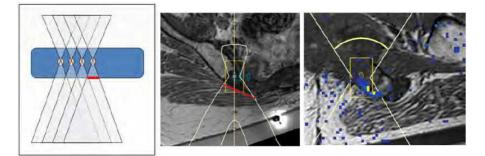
Using the broader part of the ultrasound beam to heat cortical bone surface. Right: Showing a large heating area in the bone-muscle interface.
